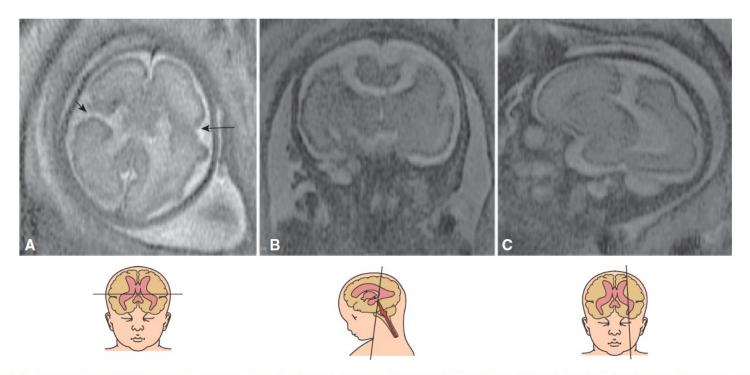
T2-weighted MRI at 28 postmenstrual weeks shows bilateral schizencephaly with multiple clefts lined by abnormal gray matter. (A) The axial section demonstrates the presence of an open lip (*arrowhead*) and a closed lip (*arrow*). Coronal (B) and sagittal (C) planes show open-lip defects lined with gray matter.
